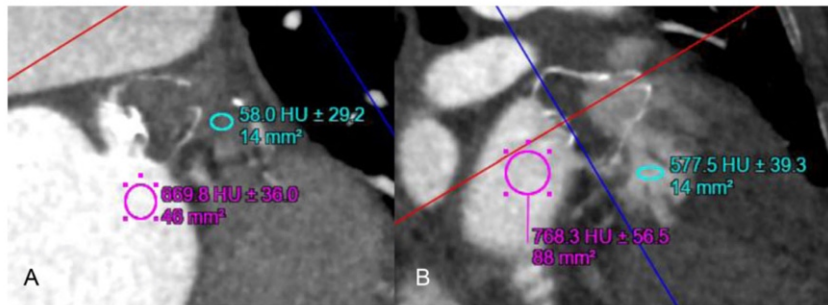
Linear attenuation coefficient measured in Hounsfield units on contrast-enhanced CT images of the LAA after WATCHMAN closures showing (A) complete occlusion of the LAA (no residual contrast patency, 58.0 HU) and (B) patent LAA (residual contrast patency, 577.5 HU).
